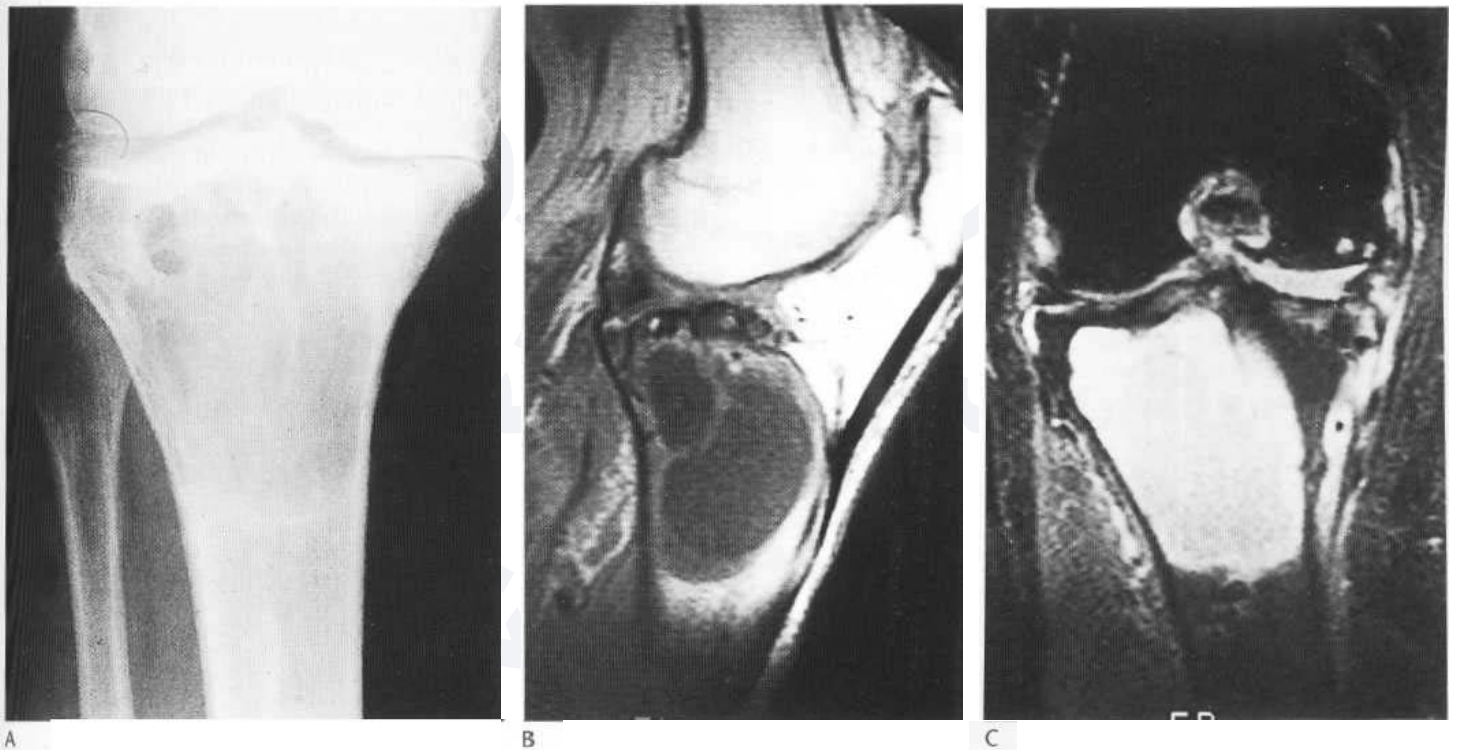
Large subarticular geode mimicking a giant cell tumour. (A) Conventional AP radiograph showing a large subarticular osteolucency with well-defined distal margins in the proximal tibia. Prominent medial compartment osteoarthritis is shown. Sagittal T₁-weighted (B) and coronal STIR (C) MR images showing the multiloculated cystic nature of the tibial geode and the well-marked knee joint osteoarthritis.
